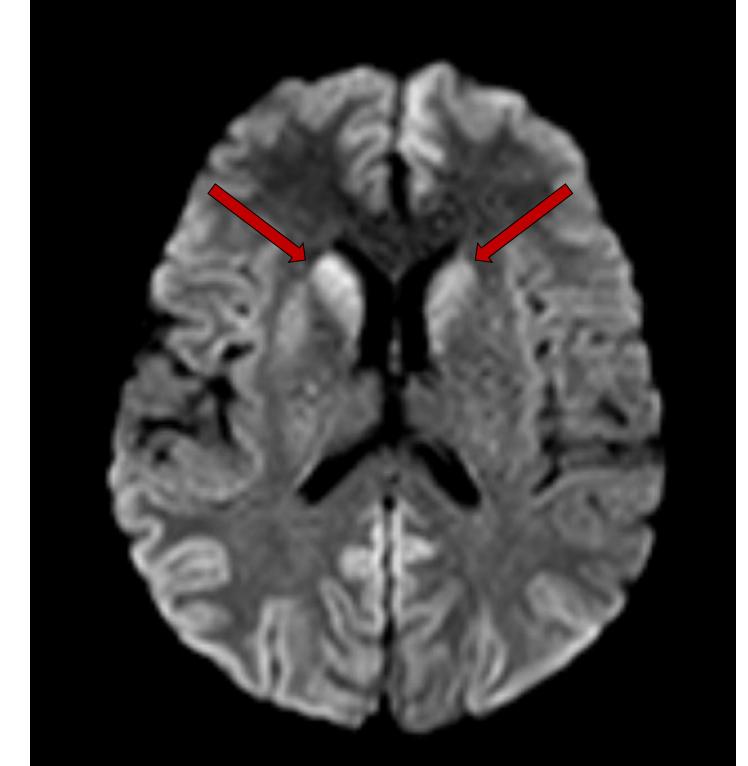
Diffusion weighted MRI image from 11/07/2023 showing symmetric hyperintensity in the bilateral basal ganglia (caudate nucleus).
